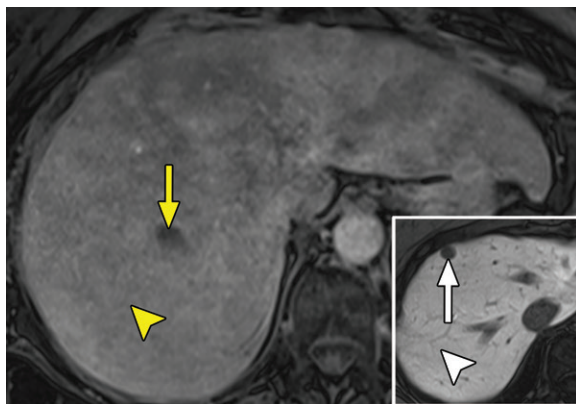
Effects of flip angle on background liver hyperintensity with gadoxetate-enhanced HBP imaging in two different patients. Axial 3D T1-weighted spoiled gradient-echo MR image shows that using a standard flip angle of 10° results in less hyperintensity of background liver (yellow arrowhead) and less contrast between normal liver and a hypointense mass (yellow arrow) compared with a flip angle of 35° (inset), which optimizes contrast between background liver (white arrowhead) and a hypointense mass (white arrow).
